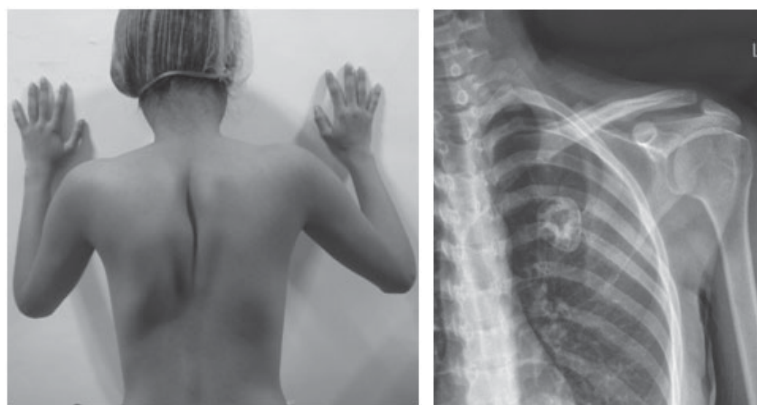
Xray showing a bony lesion arising from the medial border of scapula.
